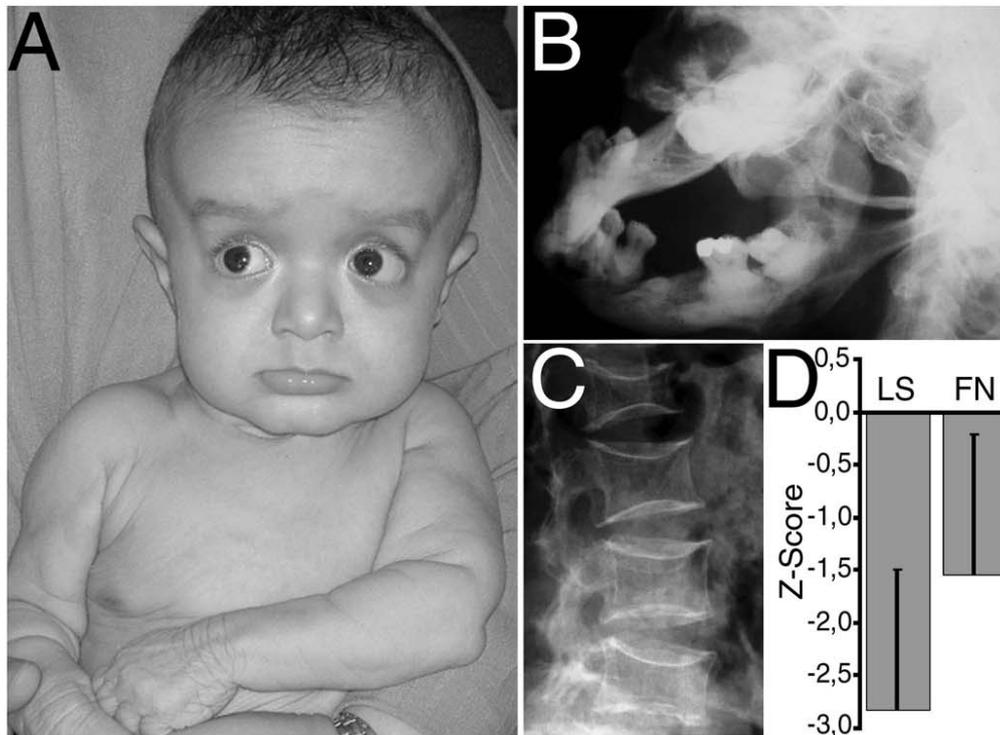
Clinical features of geroderma osteodysplasticum (GO). (A) 9-month old patient with two spontaneous femoral fractures. Note the typical facial appearance with sagging cheeks and pronounced wrinkling at the chest and dorsum of the hands. (B) Skull radiograph in a 45-year old patient showing thinning of the mandibula and tooth loss. (C) X-ray of the lumbar spine from a 34-year old female patient from Oman showing low mineral density and compression fractures of two vertebrae. (D) Bone mineral density in GO shown as number of standard deviations after age-correction (Z-score). While average bone mineral density values match the criteria for osteoporosis at the lumbar spine, the femoral neck displays osteopenia.
